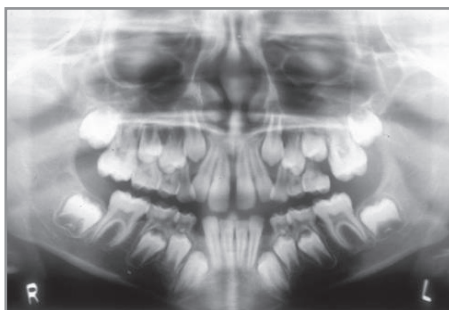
Panoramic radiograph taken 4 months after Figure 3 shows overcorrection of impacted tooth #14. Note root resorption on the adjacent primary second molar.
